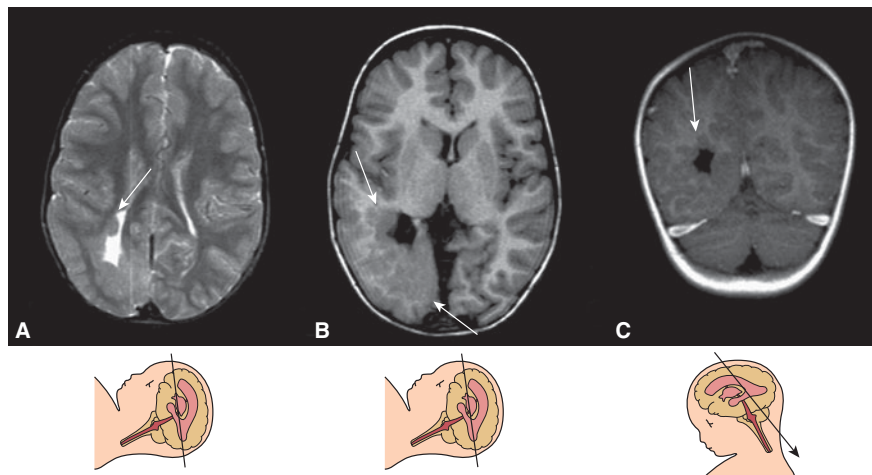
Periventricular nodular heterotopia initially evaluated due to fetal asymmetric ventriculomegaly and suspected white matter echogenicity. The girl developed complex partial seizures by the age of 2 years. The MRI was performed at the age of 5 years following the first episode of generalized seizures. T2 axial (A), T1 axial (B), and T1 coronal (C) images demonstrate periventricular heterotopia surrounding and protruding into the occipital horn and associated abnormal overlying cortex.
